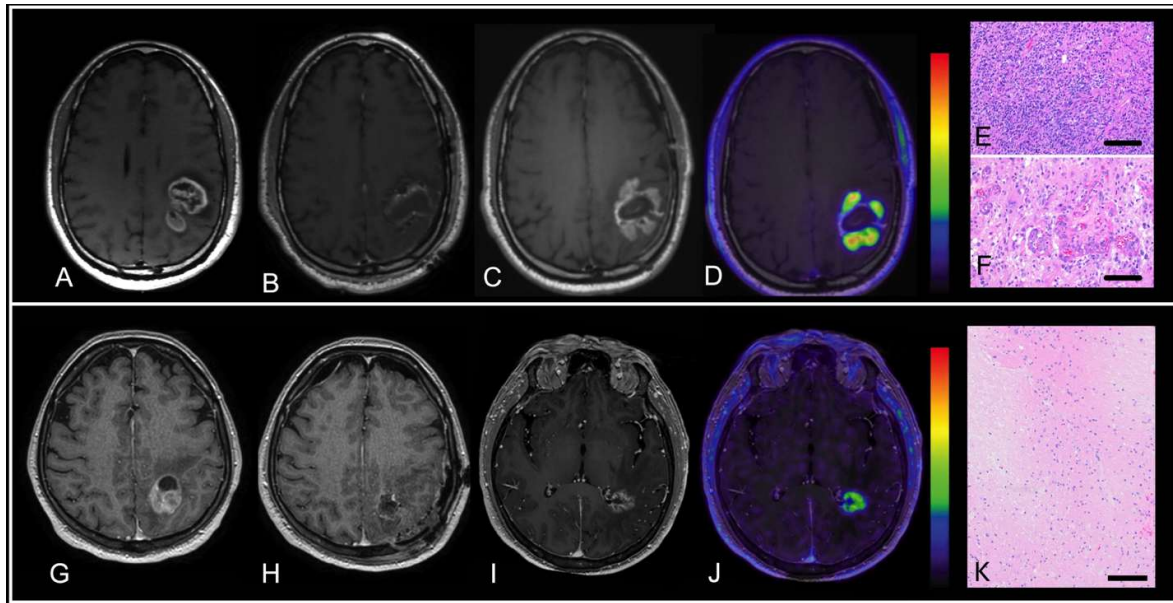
Clinical Case Examples of [F18]-Fluciclovine PET/MRI Response Assessment. Longitudinal contrast enhanced T1-weighted imaging in true disease progression (Top Row) and treatment-related changes (Bottom Row). True Disease Progression: Pre-operative imaging from a 53-year-old man with left peri-rolandic enhancing mass (A) who underwent maximal safe surgical resection (B) which confirmed MGMT unmethylated GBM. The patient subsequently was treated with standard-of-care CRT. New enhancement about the resection cavity margins, representing presumed disease progression, (C) occurred 6 months following completion of CRT. [F18]-Fluciclovine PET/MRI imaging (D) fused with T1-post contrast imaging demonstrated heterogeneously elevated [F18]-Fluciclovine avidity throughout the enhancing mass, with an SUVmax of 9.9, suspicious for true tumor progression. Subsequent surgical resection clinically validated disease status which was evidenced by marked hypercellularity (E) and microvascular proliferation (F). Treatment Related Changes: Pre-operative imaging from a 62-year-old man with a left peri-rolandic enhancing mass (G) who underwent maximal safe surgical resection (H) which confirmed MGMT unmethylated GBM. A new enhancing lesion inferior and medial to the resection cavity in the peri-atrial white matter, representing presumed disease progression, (I) occurred 16 months following completion of CRT necessitated [F18]-Fluciclovine PET/MRI imaging (J) fused with T1-post contrast imaging. Homogenous [F18]-Fluciclovine avidity throughout the enhancing mass demonstrated focal SUVmax of 4.7 suggested treatment related changes. Subsequent surgical resection (K) clinically validated disease status which was evidenced by necrotic parenchyma (left), minimally atypical glial cells (middle), hyalinized blood vessels vasculopathy (not shown). Scale bar in PET/MRI fused images: PET Rainbow color scale, set to maximum SUV 0-7.
